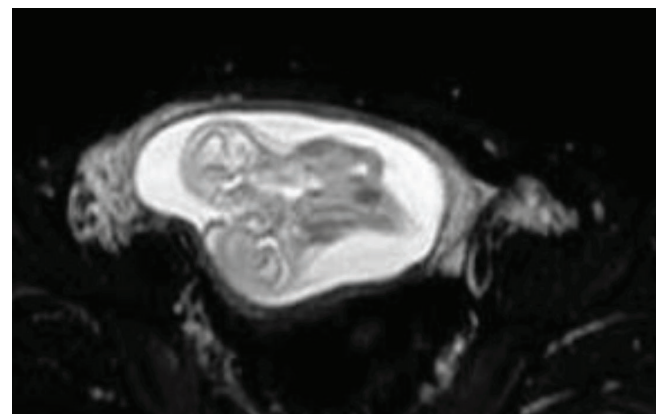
Antenatal MRI showed fused chest wall, scoliosis, single Liver and Heart confirming the diagnosis.
